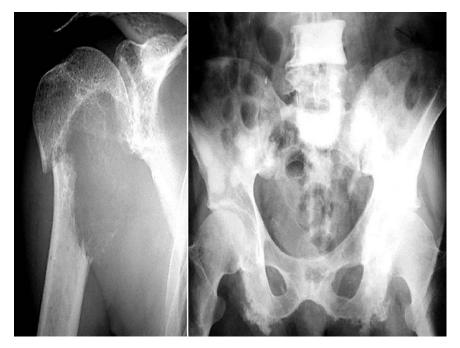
Representative plain-film radiographs of a lytic metastasis of renal cell carcinoma in the humerus (left) and blastic metastases of prostatic adenocarcinoma in the vertebrae and pelvic bones (right).
